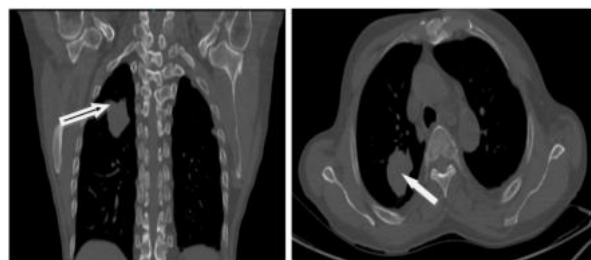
Coronal and Axial CT showing isodense mass in right upper segment.
